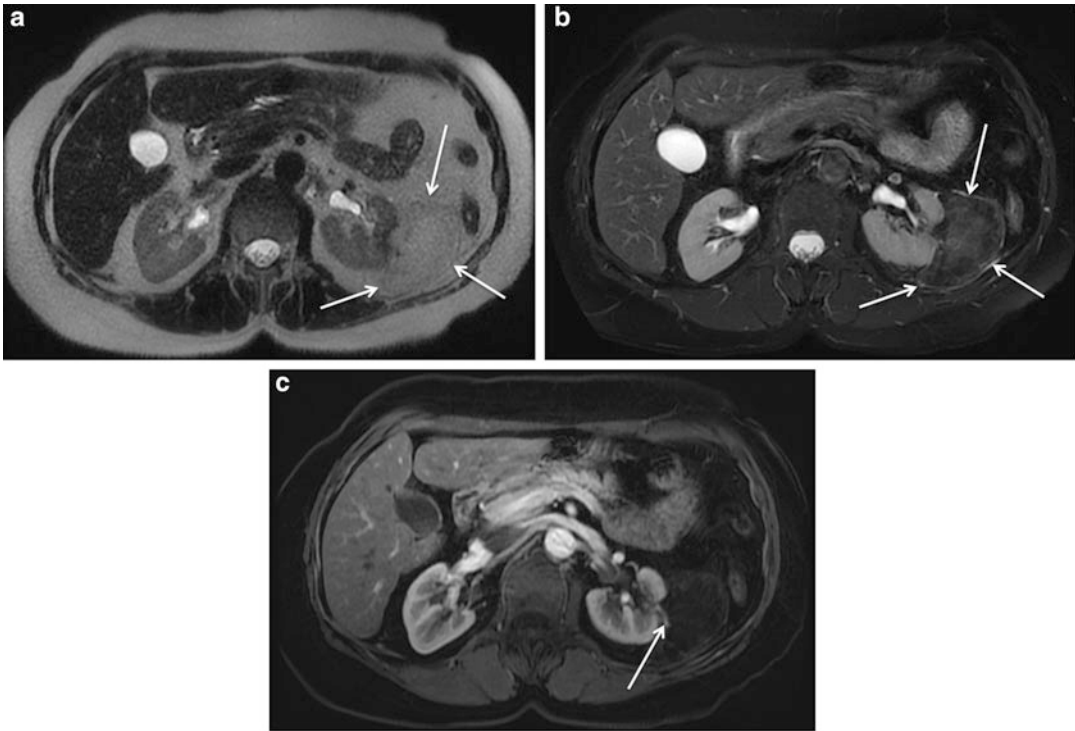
Angiomyolipoma. (a) The axial T2-weighted image shows an exophytic lesion arising from the lateral aspect of the left kidney (*arrows*) with signal intensity matching retroperitoneal and subcutaneous fat. (b) The fat-suppressed T2-weighted image demonstrates virtual complete elimination of signal from the lesion (*arrows*)
